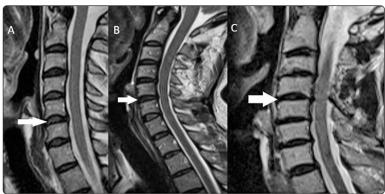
Nucleus signals in T2-weighted images. (A) No signal loss, (B) moderate signal loss, and (C) total loss.
